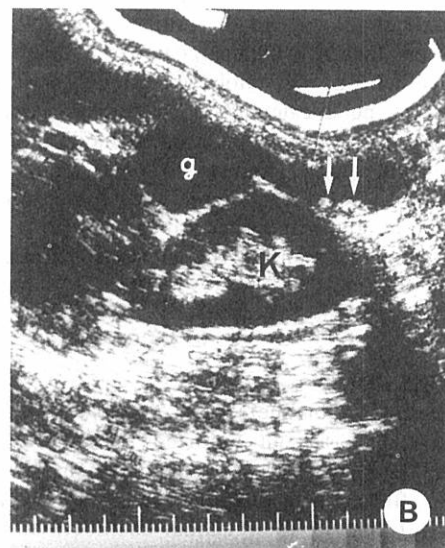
(MF [redacted]). A. Oral cholecystogram shows an aggregate of approximately 20 calcific densities, apparently outside the gallbladder. B. Sagittal ultrasonography shows a bicameral gallbladder (g) and calculi in its fundal chamber (arrows). K=right kidney.
